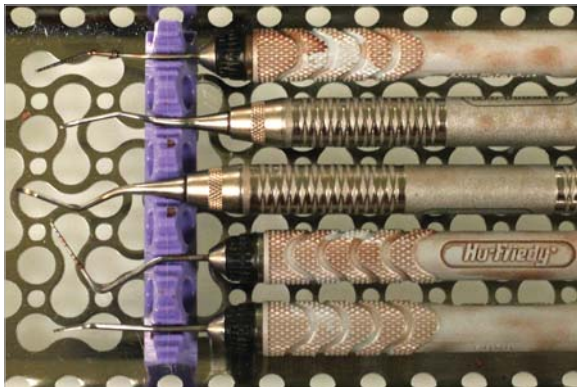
Cleaned instruments after a single 10 minute ultrasonic cycle.
